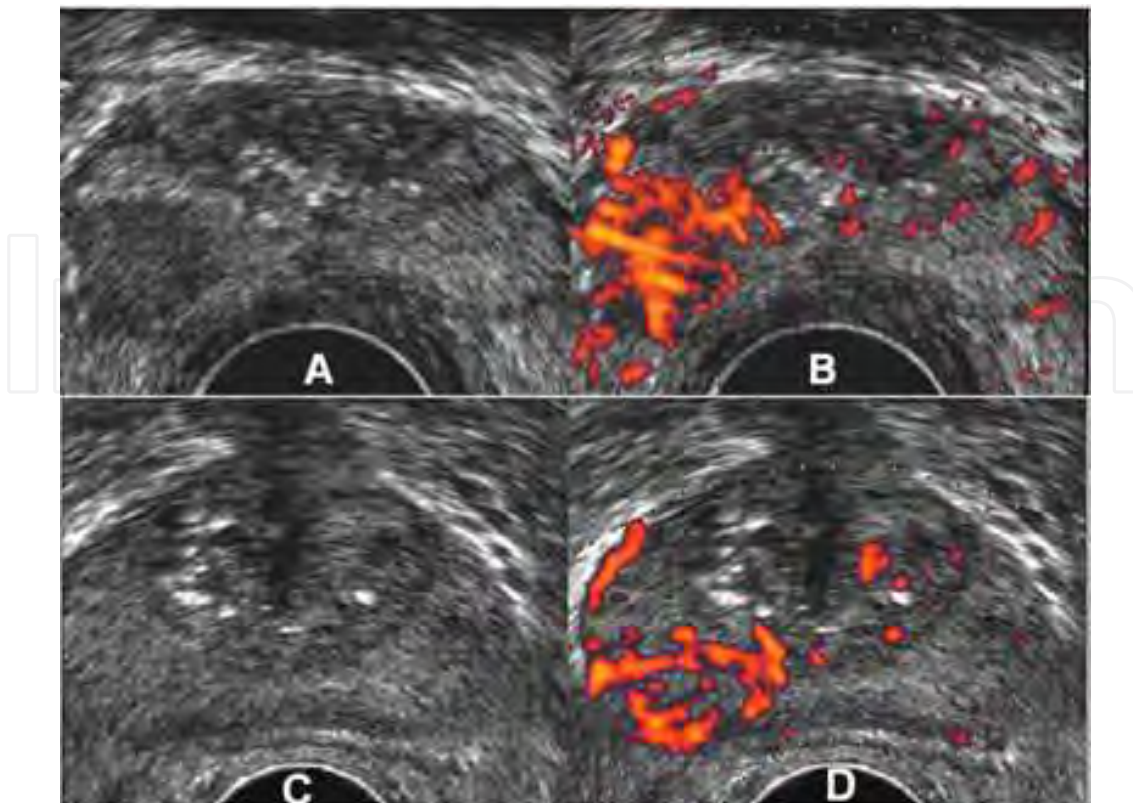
(A) TRUS show a hypoechoic lesion in the right posterolateral aspect of the peripheral zone proved to be cancer. (B) The same area is hypervascular in power Doppler (C) TRUS in another patient with prostate cancer shows no evident focal lesion in grey scale US. (D) Power Doppler of the same patient show focal area of increased vascularity in the right side of the peripheral zone proved to be carcinoma by targeted biopsy
